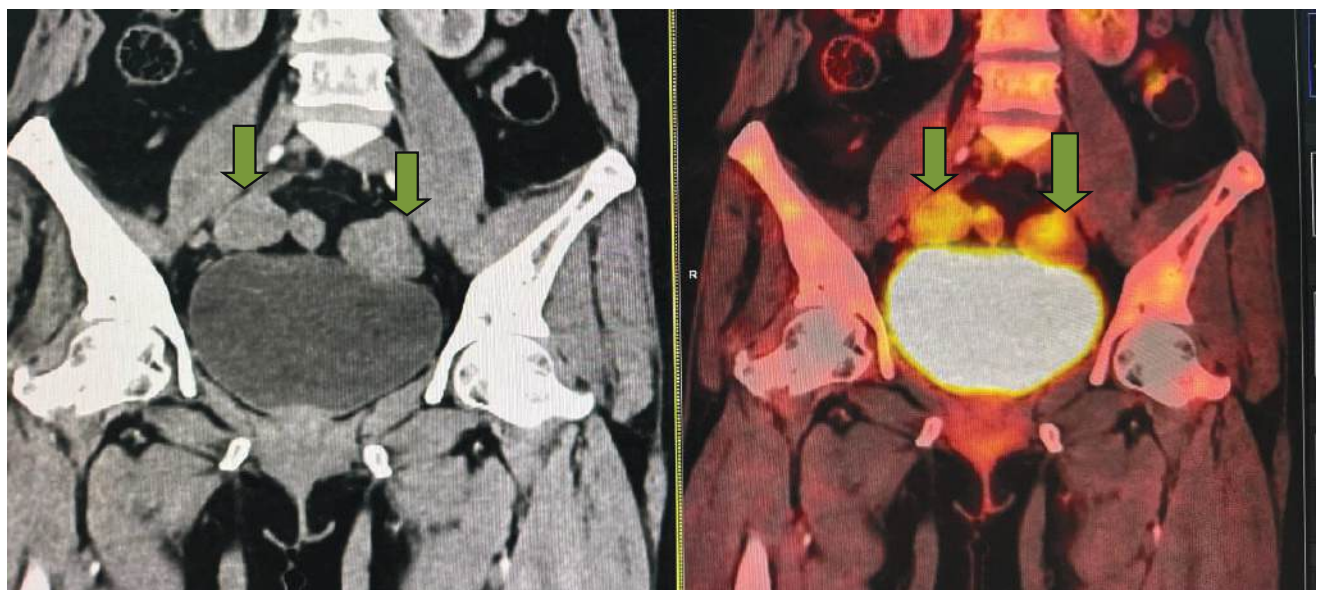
Bilateral ovarian metastases (Krukenberg tumor) from primary breast carcinoma (post treated). Heterogeneously enhancing FDG avid (SUV: 6.02) lesions are noted in both ovaries (green arrow).
